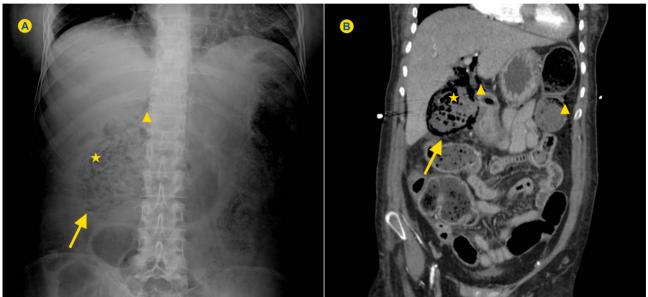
Abdominal radiograph (A) and coronal reformatation of a contrast-enhanced computed tomography scan (B) of the abdomen and pelvis, depicting gas within the gallbladder wall (arrow) and lumen (star) and pneumoperitoneum (arrowhead)
